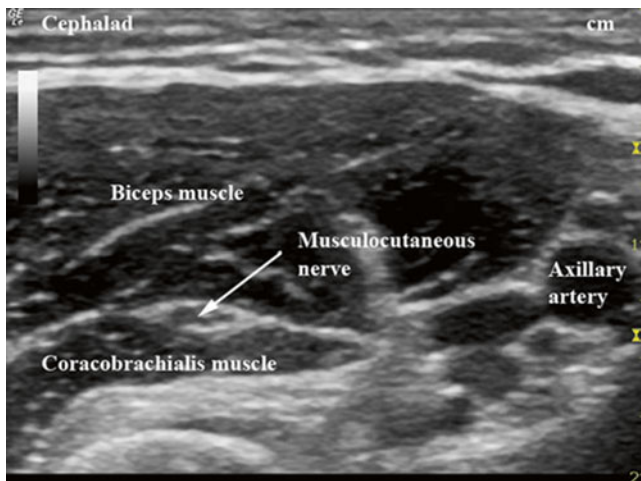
Ultrasound anatomy of the musculocutaneous nerve (With permission from Buckenmaier and Bleckner [71])
